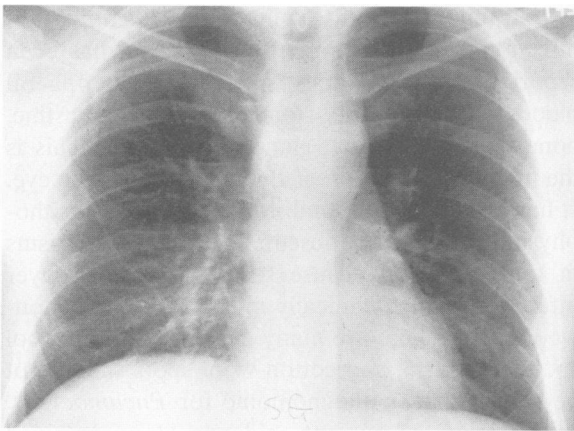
X-ray study of the chest showing diffuse infiltrates that proved to be pulmonary Kaposi's sarcoma on bronchoscopy and subsequent autopsy evaluation.
